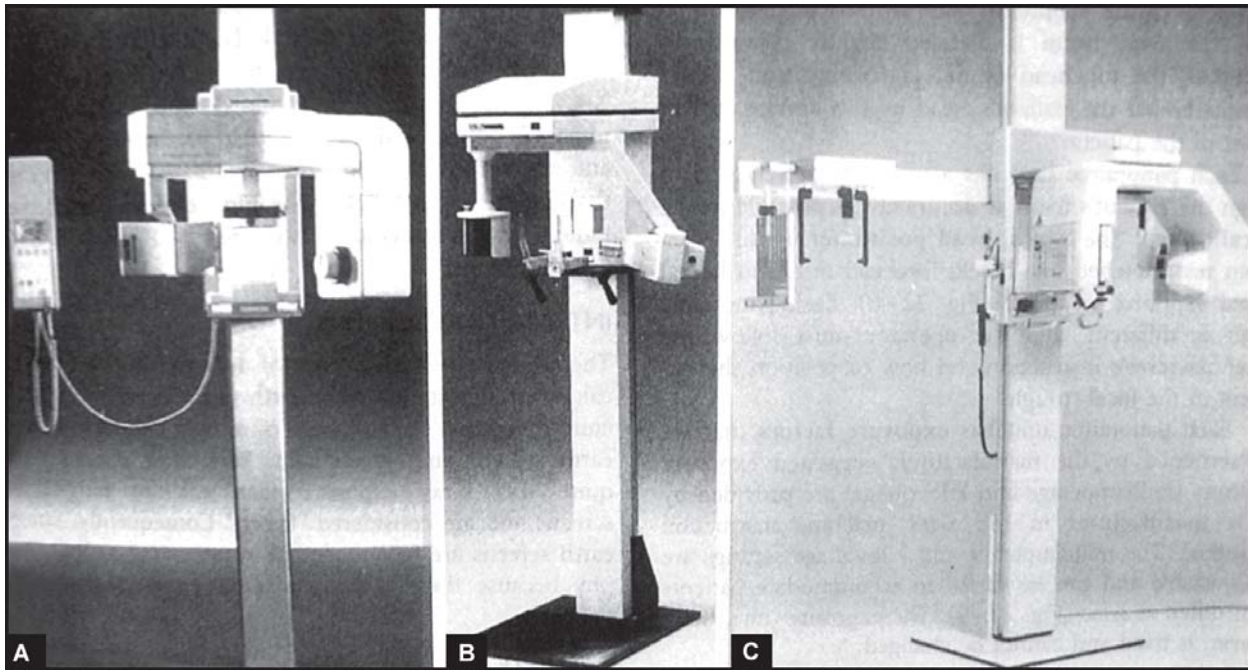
A. The orthopantomograph 10E extraoral machine. B. The GX-Pan extraoral X-ray machine. C. The cranex 3 cep extraoral X-ray machine
